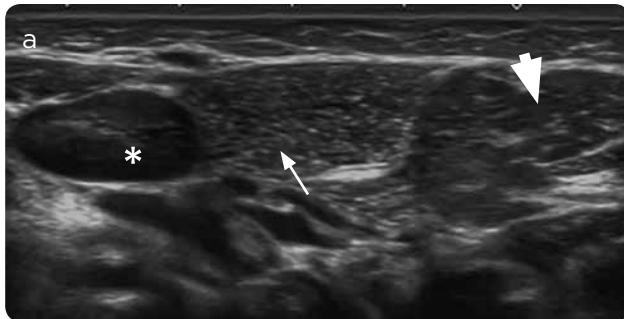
a) Ultrasound and b) MR with axial T1 information: mass (short arrow) posterior to the right (arrowhead) and anterior submandibular gland and lateral to the carotid space (long arrow). The jugulodigastric ganglion (asterisk) can also be observed on ultrasound.
